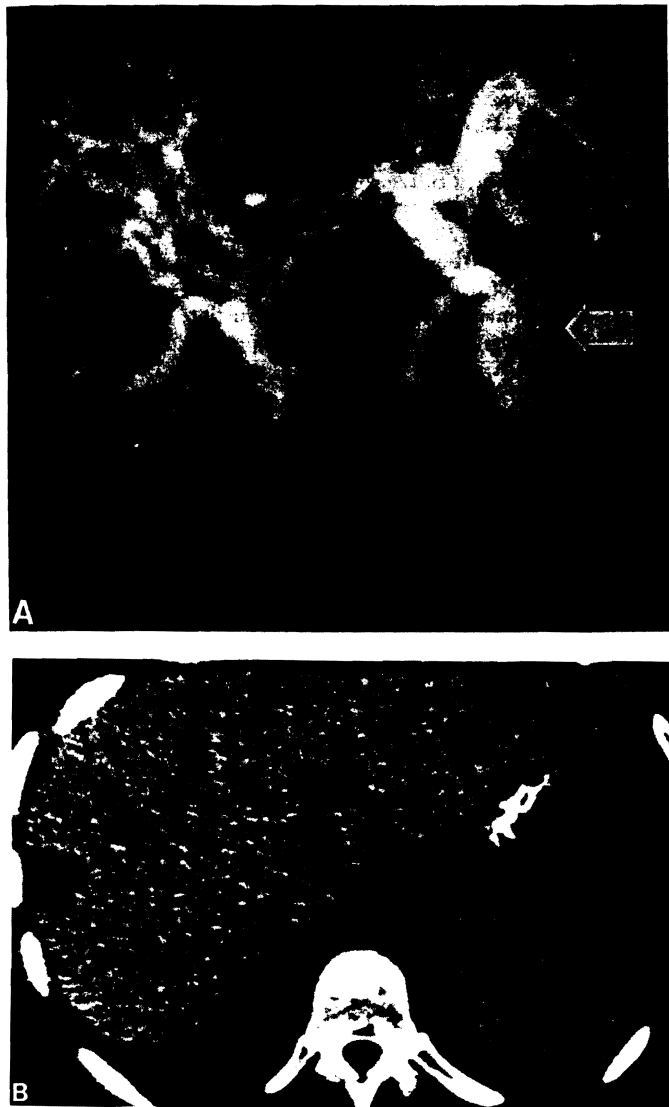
(A) Large pseudoaneurysm (arrow) at the hepatic artery anastomosis demonstrated on selective hepatic arteriogram. (B) Area of decreased attenuation (arrow) in periphery of right lobe representing a hepatic infarct demonstrated on CT scan.
